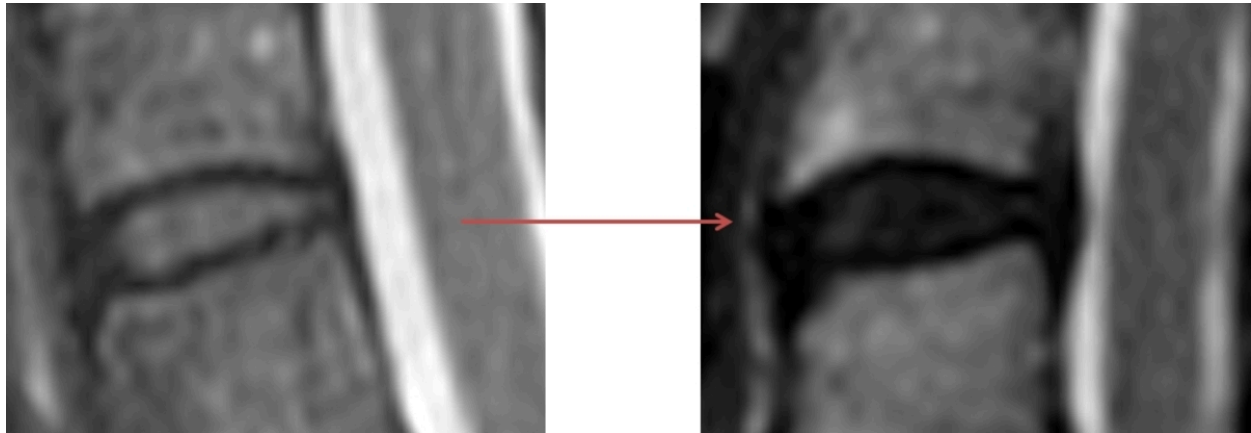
a) Hydrated disc. b) Dehydrated disc. Sagittal T2-weighted images.
